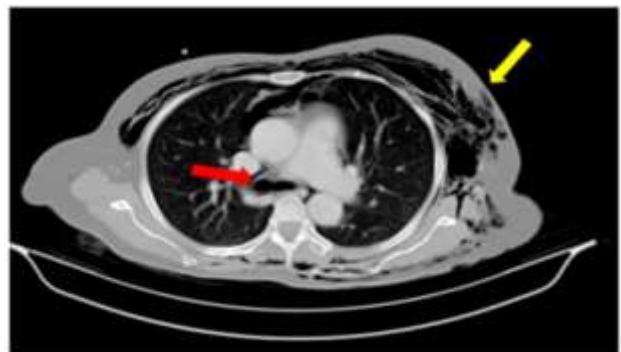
An axial view of CT scan of the chest (lung window) showing subcutaneous emphysema of chest wall (yellow arrow) and pneumomediastinum (red arrow).
